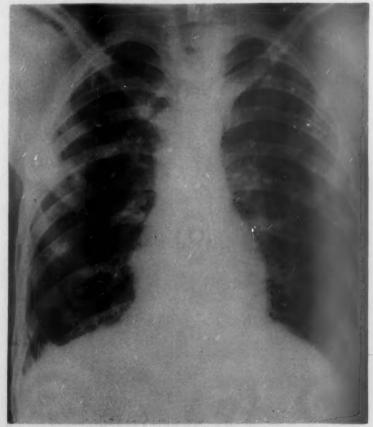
Third hospital day roentgenogram, showing increased nodular densities in both lungs.
